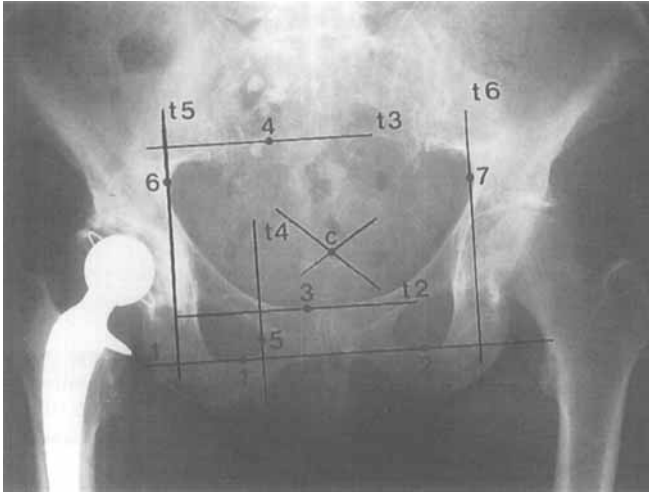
The tangents t1–t6 are defined and digitized by 7 points 1–7. The point c marks the approximate center of the radiograph.
